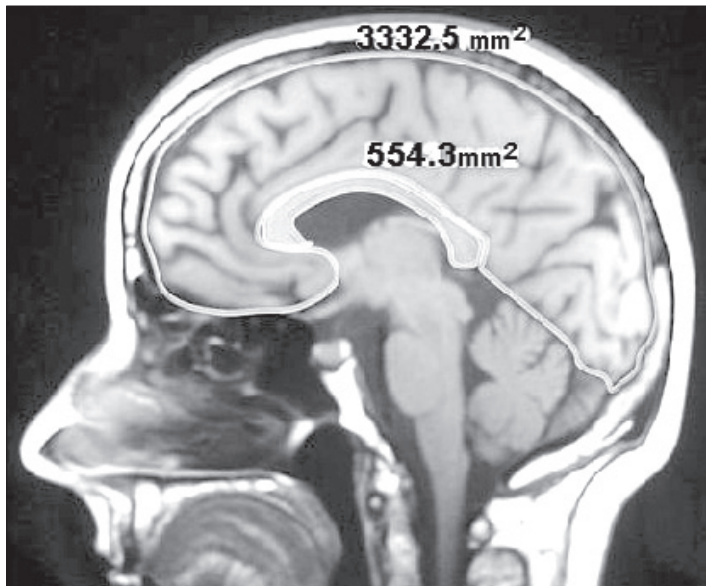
Sagittal T1-weighted MR image demonstrates the area measurements for index calculation.
